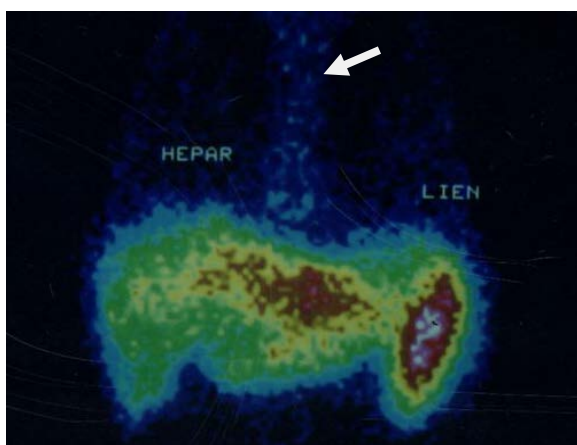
Static scintigraphy of liver. Heterogenous distribution and decreased accumulation of radiocolloid. Anhepatic hyperfixation of radiocolloid shows high accumulation in the lien area (up to 40-50 %) and bone marrow (arrow). Cirrhosis of liver
